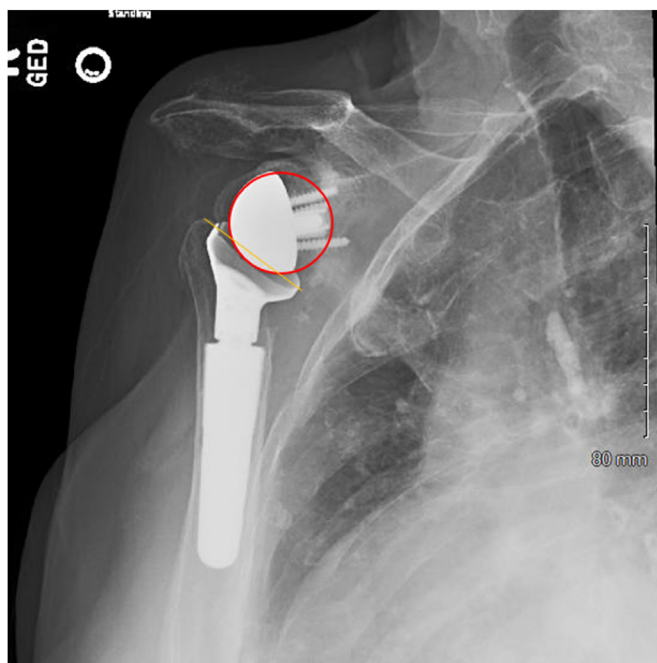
Right shoulder X-ray demonstrating an inlay right reverse total shoulder arthroplasty (Lima SMR Humeral component; Lima Corp., Arlington, TX, USA) A with metaphyseal portion reamed within bone and the articulation occurring below the level of resection (yellow line).
